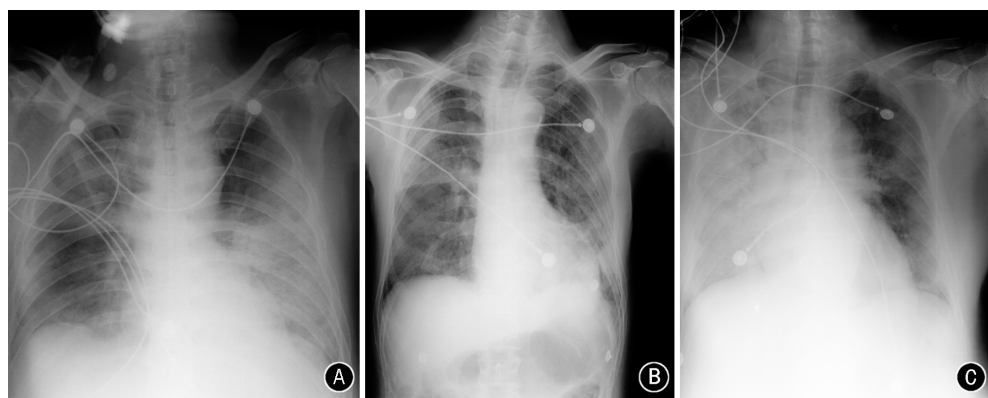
Chest X-ray of three patients shows the distribution of the disease: diffuse (A), multifocal (B), diffuse (right) and multifocal (left) (C), and the pattern of the disease: ground glass opacities and consolidations.
